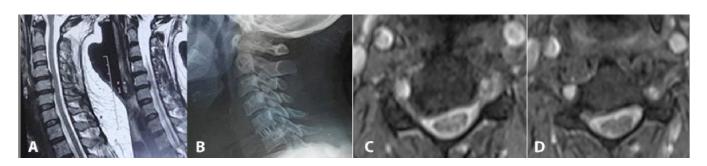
Female patient 40 years old presented with RT brachialgia (NRS 8) and neck pain (NRS 4). (A) MRI preoperative showing C4-5 and C5-6 CDP. Only C6 had positive SNRB. (B) X-ray postoperative after ACDF for C5-6. Brachialgia improved after surgery (NRS 0) and neck pain (NRS 2). (C) Axial cut of C4-C5, (D) Axial cut of C5-C6.
